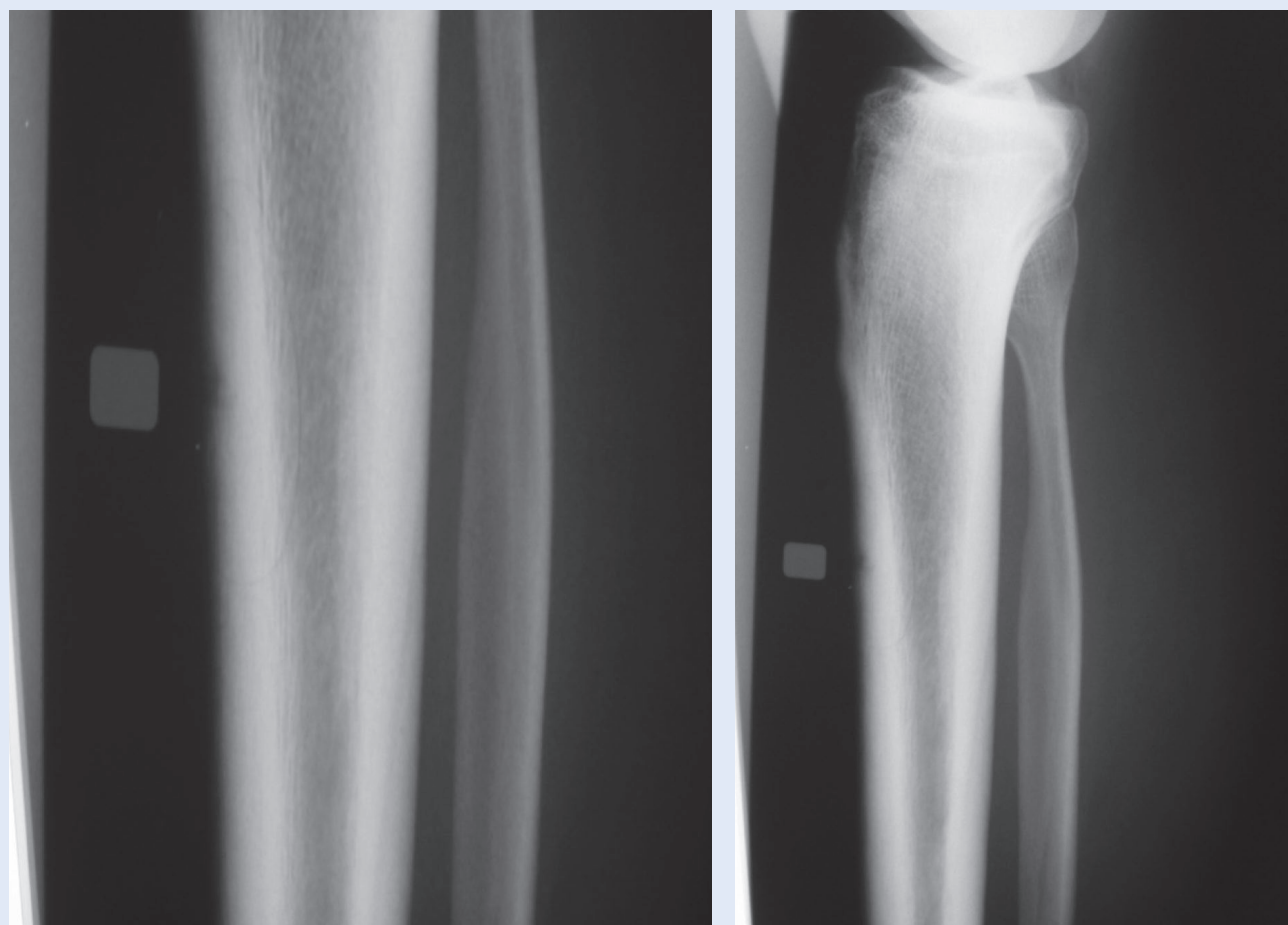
May 2007; X-ray of the right lower leg – in the area of ventral tibia, in proximal methaphysis, transparent focal point within the compact bone
